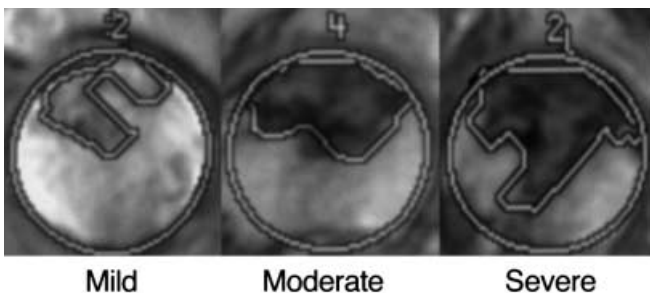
The grade following the extent of lesion in MRI: mild, moderate, severe
